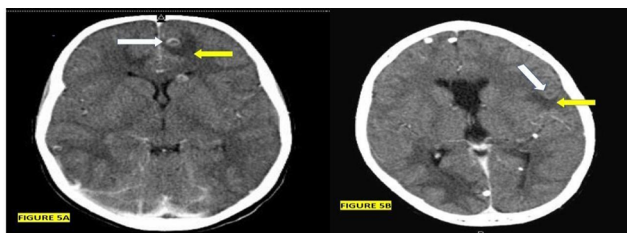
(A) An axial view of a post-contrast CT scan of the brain showing a ring enhancement of cysts with an eccentric scolex (white arrow) and perilesional oedema (yellow arrow); (B) An axial view of a post-contrast CT scan of the brain showing a ring enhancement of cysts with an eccentric scolex (white arrow), perilesional oedema (yellow arrow), and bilateral calcifications
